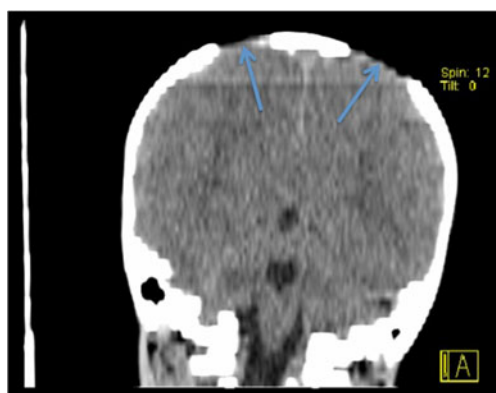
Coronal head CT noting the bilateral enlarged parietal foramina in a child with headache
